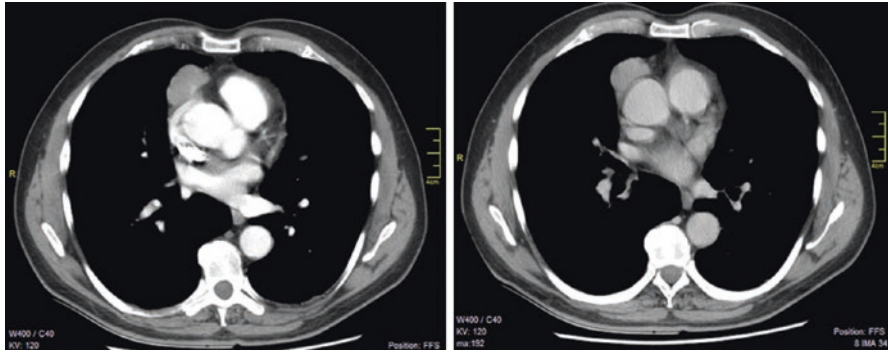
Chest CT with contrast: infiltrating thymoma. Presence of hypodense tissue that seems to infiltrate the pericardium
